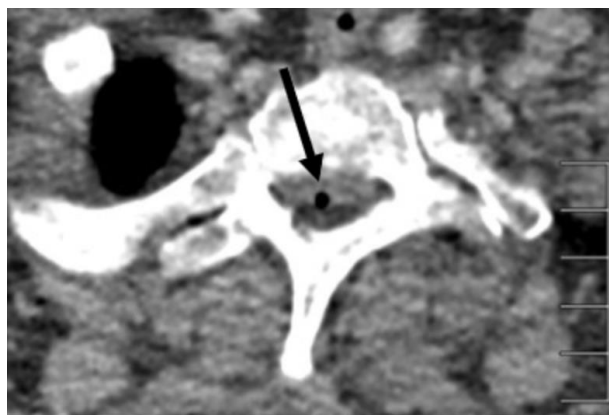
CT scan of the thoracic spine demonstrating a focus of intraaxial air at T2. CT, computed tomography.
